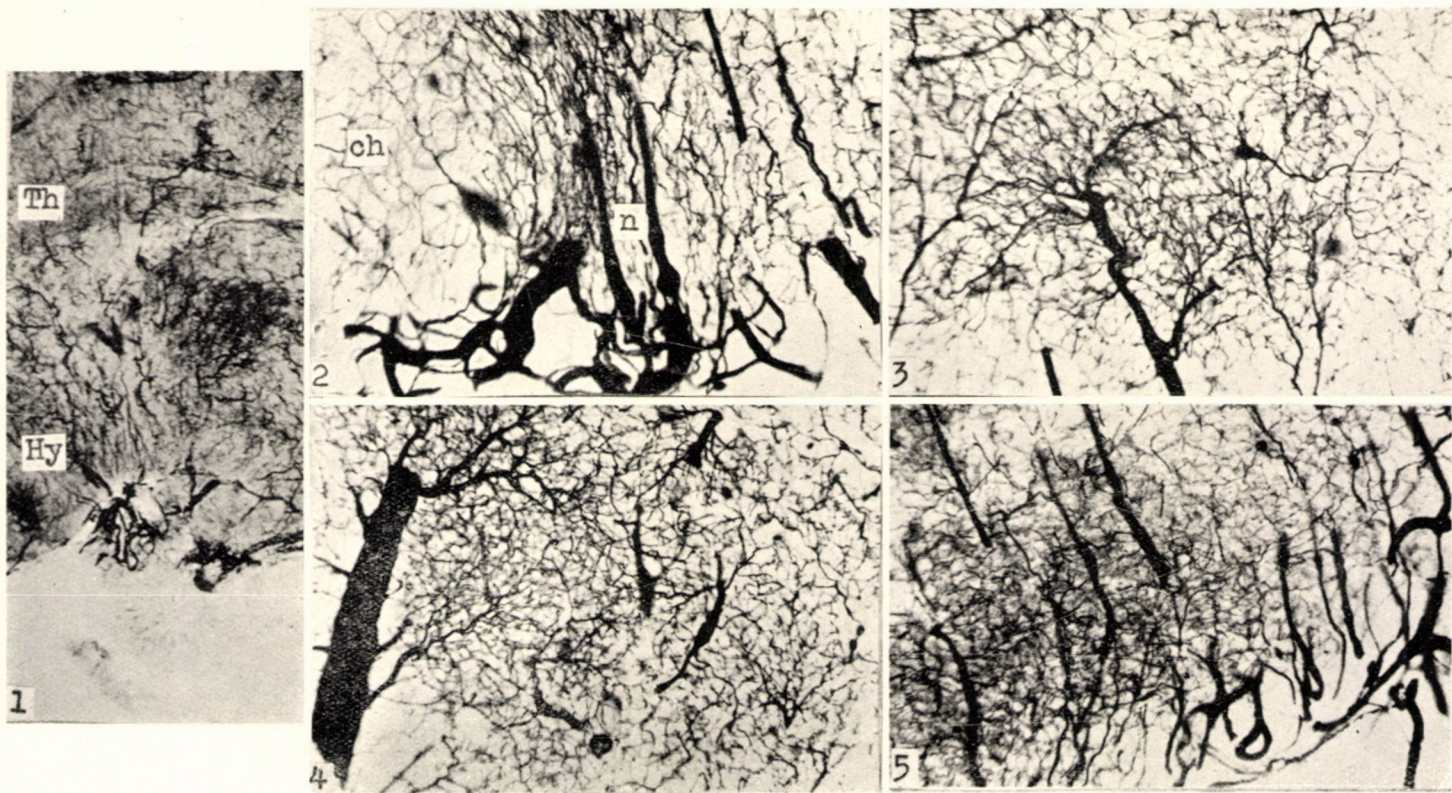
Man. Vessels of hypothalamus and thalamus. Injection with X-ray contrast material Radiograph; natural size.
